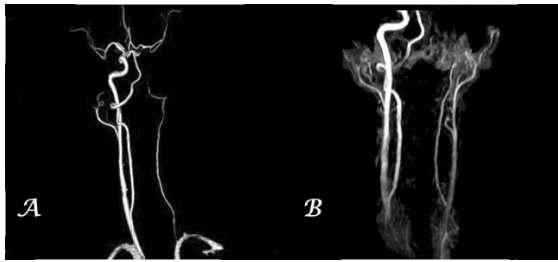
Volume Rendered CTA (A) and 3D TOF MIP MRA (B) images shows Partial stenosis of left CCA with non-visualization of distal segment of left ICA representing thrombosis.
